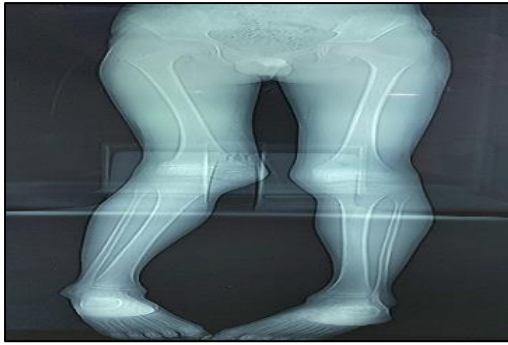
Pre-procedure radiographs.
